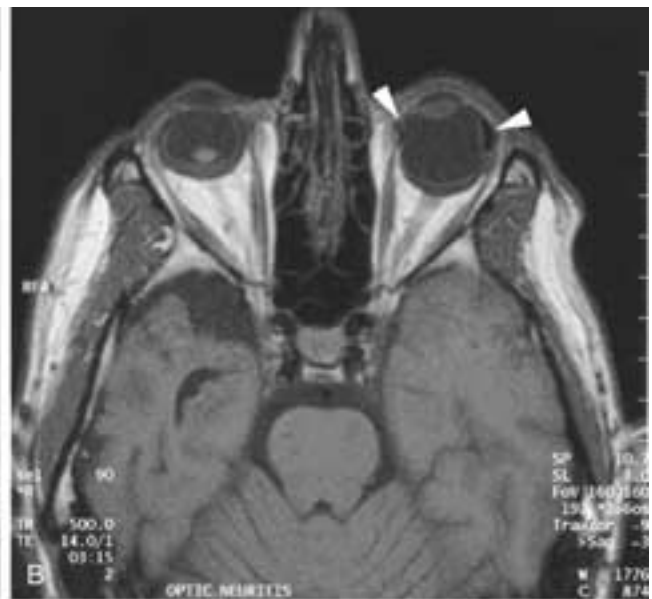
Dislocated lens, right eye; scleral buckle, left eye. MR imaging. A, Axial T1-weighted image shows the dislocated lens (*arrow*) posteriorly positioned in the right globe. B, Axial T1-weighted axial image. On the left side, the low-signal areas (*arrowheads*) on the medial and lateral aspect of the globe represent the scleral buckle. C, Axial T2-weighted image shows the dislocated lens on the right and the scleral buckle (low signal) on the left.
